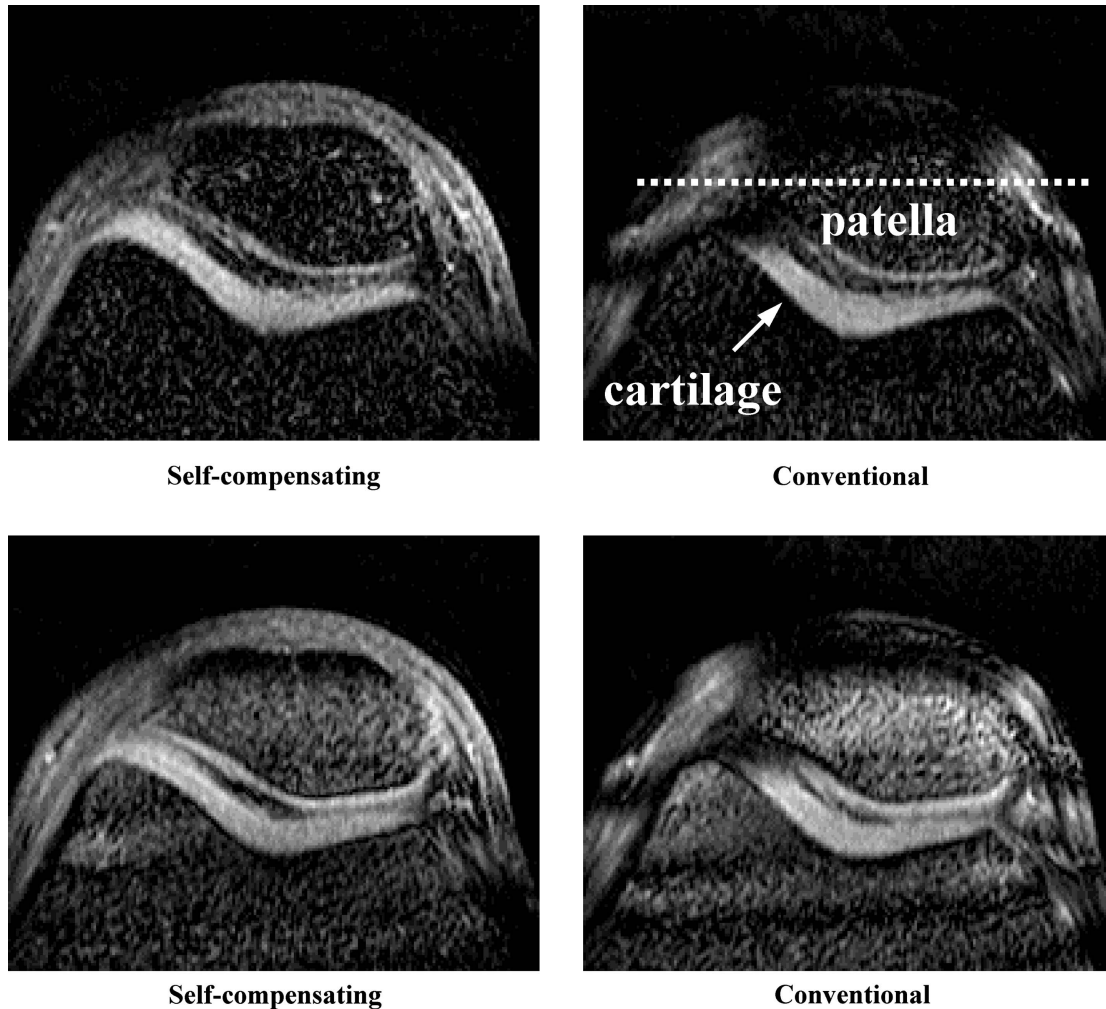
In vivo $T_{1\rho}$ -weighted axial MR images of the human knee joint obtained with a surface coil with the self-compensating and conventional pulse sequences. Severe artifacts are visible in both images obtained with the conventional sequence particularly in the regions of the patella and surrounding cartilage. The reduction of these artifacts is clearly appreciable in the self-compensated images (dotted line indicates the location of the plane of the surface coil during image acquisition).
